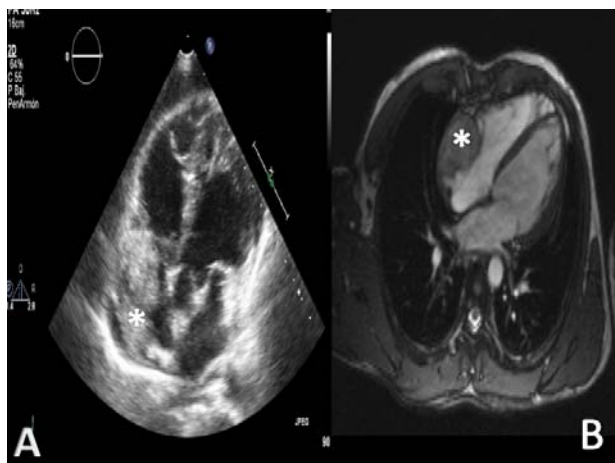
(A). Transthoracic echocardiography shows a large mass (50 × 45 mm) that protrudes into the right atrium (*). (B) Cardiovascular magnetic resonance imaging showed a large eccentric and homogenous tumor (64 × 54 × 53 mm) in the right atrial free wall, that protrudes into the right atrium (*).
